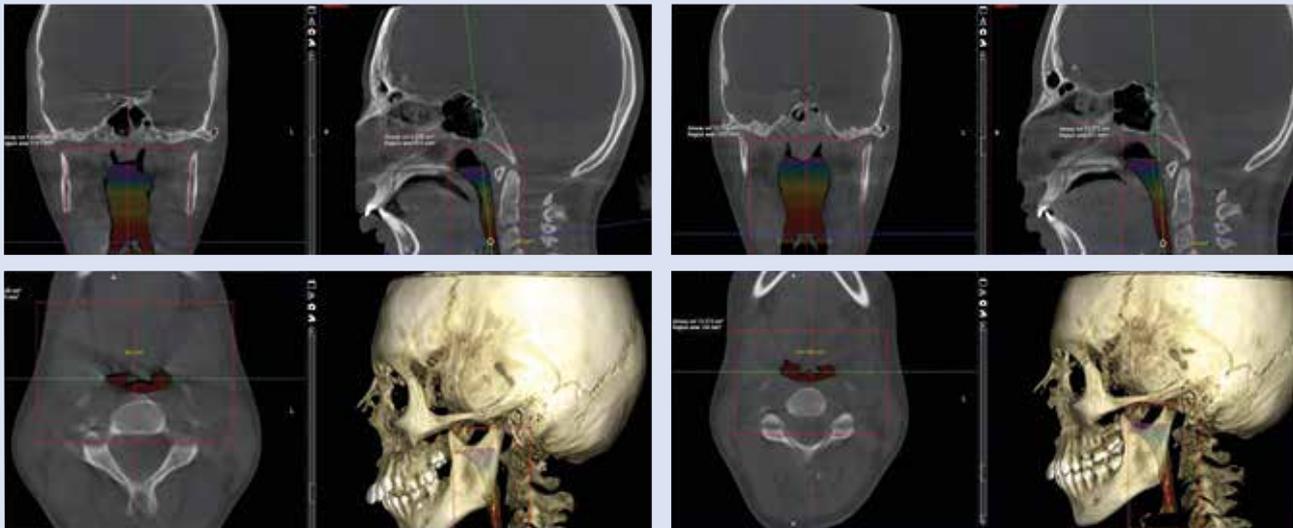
CBCT showing the improved tongue position, jaw position, tooth angulation and airway volume.
